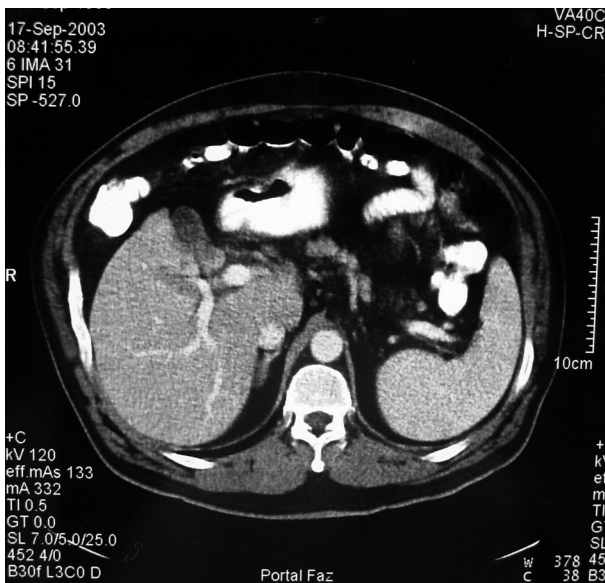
Abdominal CT scan : Marked thickening of the gallbladder with direct extension into the left liver lobe.
